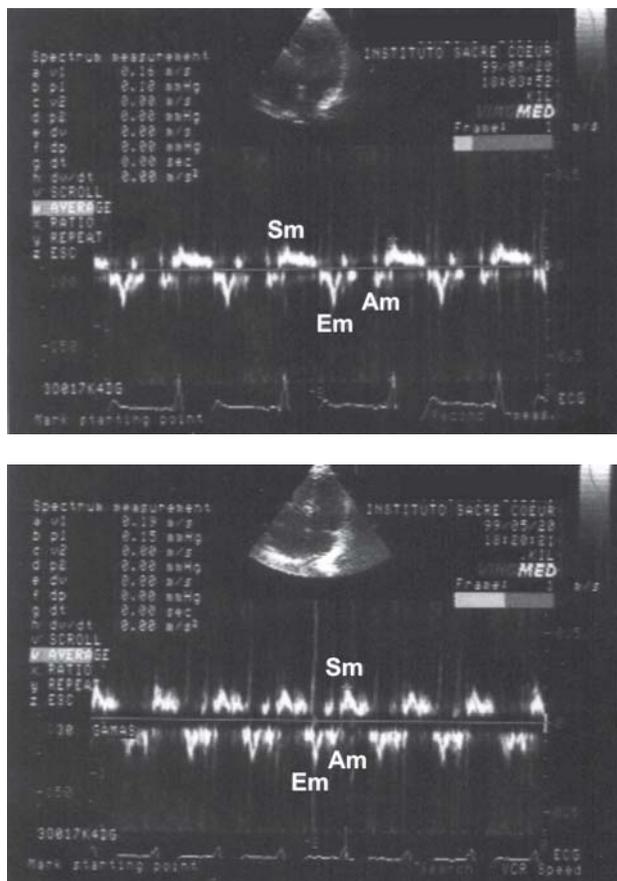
Recording of Doppler Tissue Imaging obtained from a patient with Chagas disease. Apical 4-chambers view, with sample volume of 5 mm located at the mean septal segment of the left ventricle. Baseline recording (*top image*) and with dobutamine maximum dose (*lower image*) can be observed.
